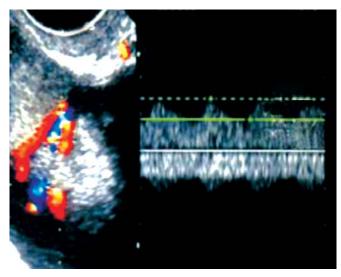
A malignant ovarian tumor with its characteristic image created by a solid counterpart. Pulsed Doppler waveform analysis shows lowresistance to blood flow
